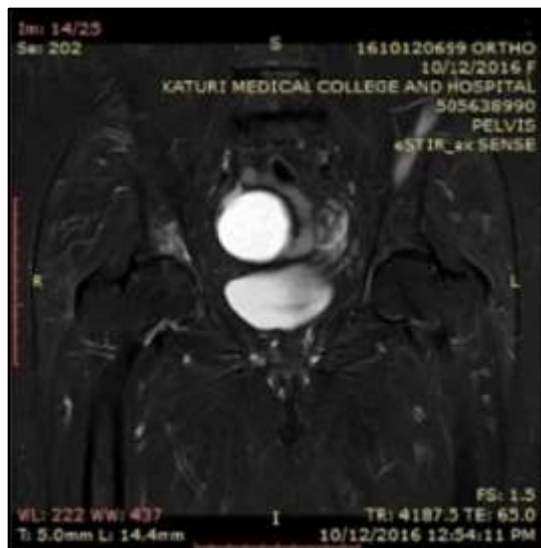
MRI CORONAL STIR Images showing Right Joint Space Reduction, Irregular Contour of Femoral Head and Atrophy of Muscles around Hip Joint in Patient with Osteoarthritis
